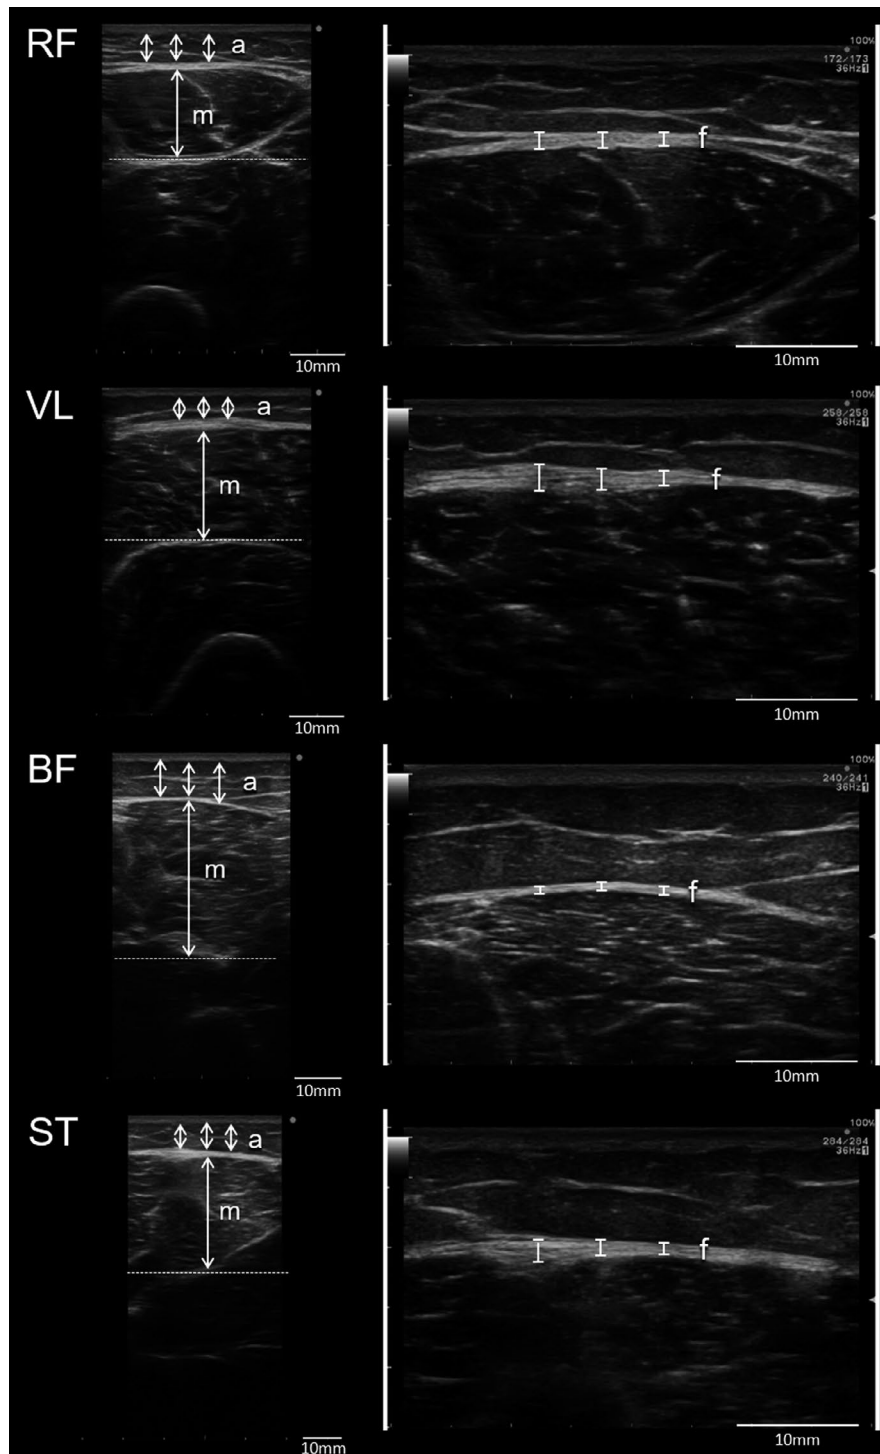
The typical images of the B-mode ultrasonography. The arrows show the measurement parts of the subcutaneous adipose tissue, fascia lata, and skeletal muscle thickness at each site. a, f, and m mean the subcutaneous adipose tissue, fascia lata, and skeletal muscle respectively
